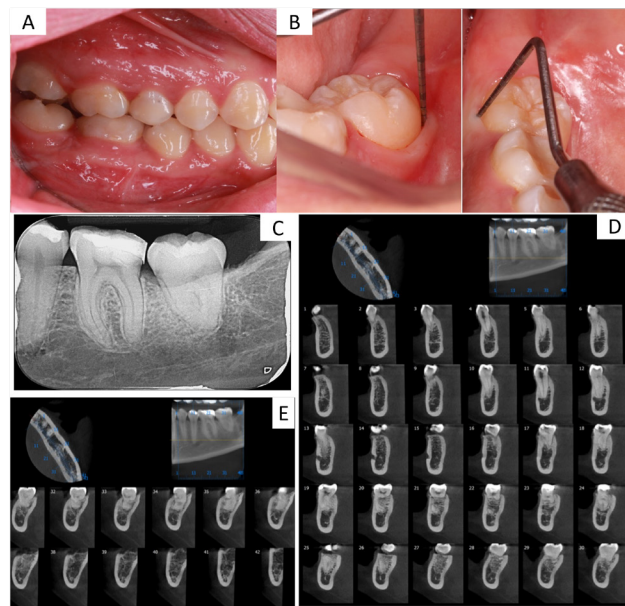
A) Lateral view showing satisfactory occlusal relationship. B) Probing showing periodontal health. C) Periapical radiography. D) Cone beam tomography
